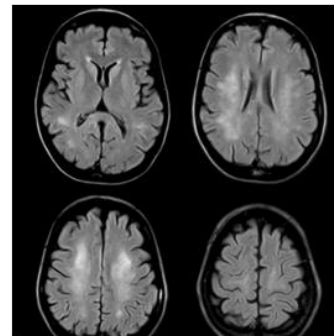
Samples of brain MR image
